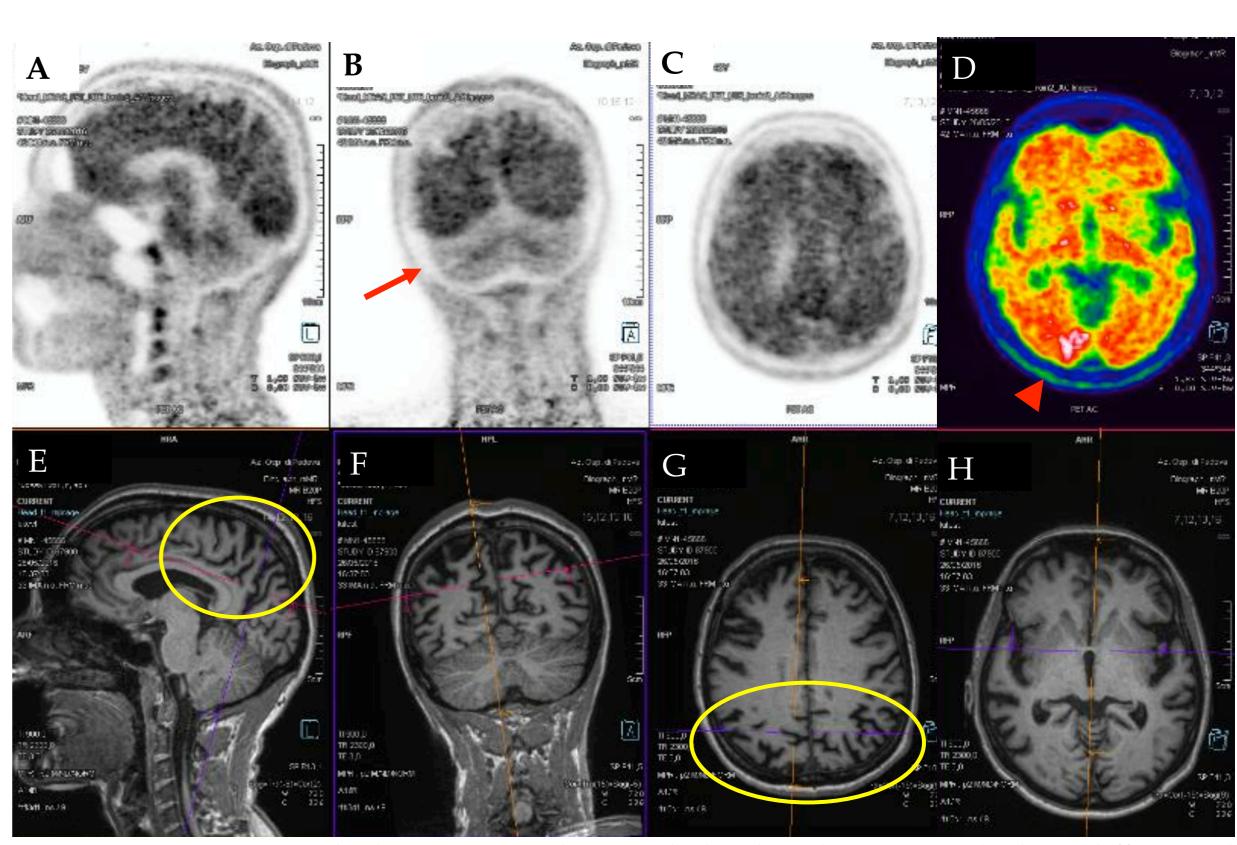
PET/MRI amyloid imaging with 18F-Florbetaben (A, B, C, D) show diffuse and significant cortical Florbetaben retention (note the cerebellar cortex as a reference region, arrow), with semiquantitative measures (D): z scores (vs 10 normal controls with age < 60) max values for: R occipital 20.1, L occipital 15.8, R parietal 14.6, L parietal 15.5 (arrow point on R occipital lobe). Note on MRI images, precence of mild parietal cortical atrophy (circles)
